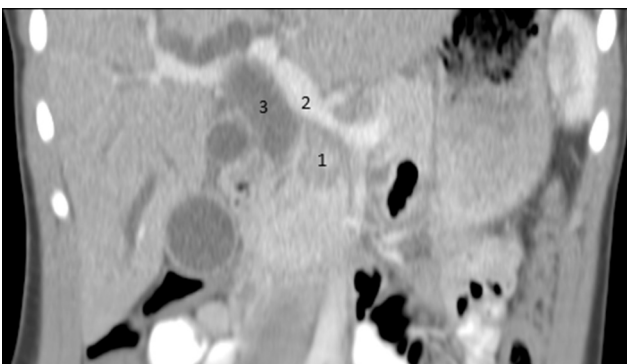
Coronal slice from computed tomography (CT) scan of the abdomen: pancreatic mass (1), portal vein (2), and dilated common bile duct (3).
